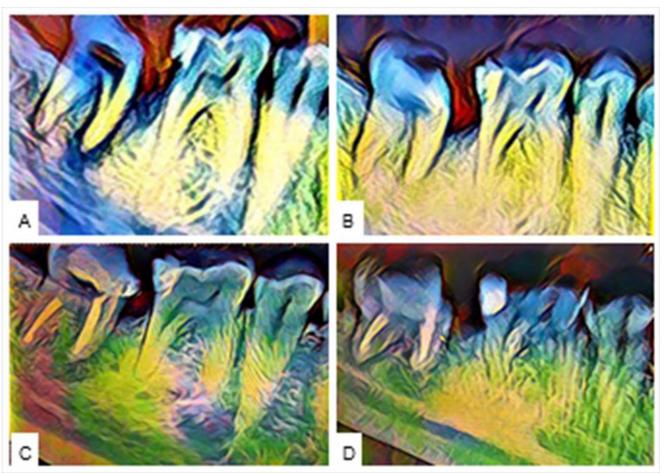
Radiographs analyzed in bioimpedance software.
